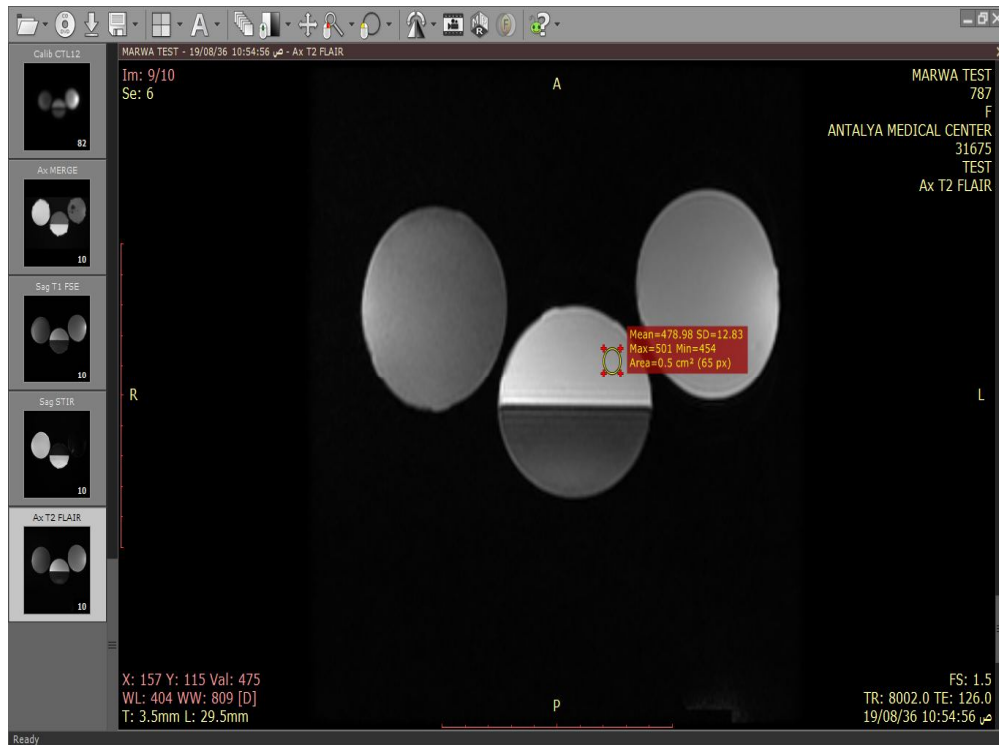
AX T2 FLAIR image taken by GE MRI 1.5T in Antalya medical center.
